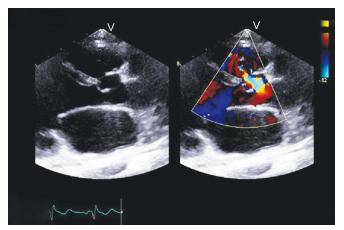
A 0.7 cm defect seen secondary to the ruptured sinus of Valsalva in transthoracic echocardiography in the parasternal long-axis view
